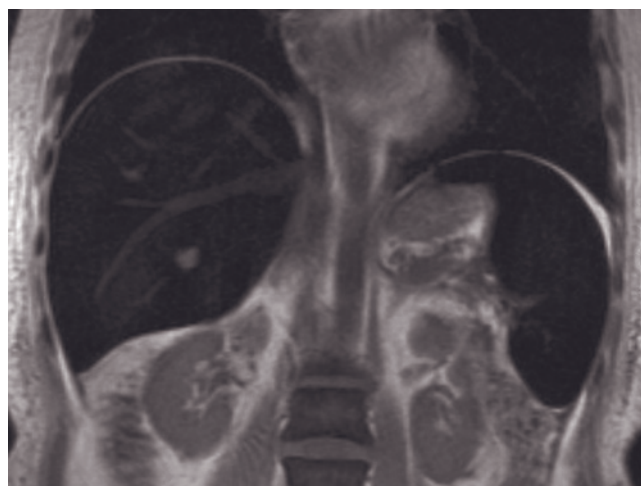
Transfusional siderosis, massive. Coronal SS-ETSE (a), T2-weighted fat-suppressed ETSE (b), SGE (c), and immediate postgadolinium SGE (d) images. Massive iron deposition is present in the liver, spleen, and pancreas (a–c), demonstrated by signal-void liver, spleen, and pancreas. Magnetic susceptibility causes a “blooming” appearance surrounding the pancreas (c). These organs remain signal void after gadolinium administration (d).
